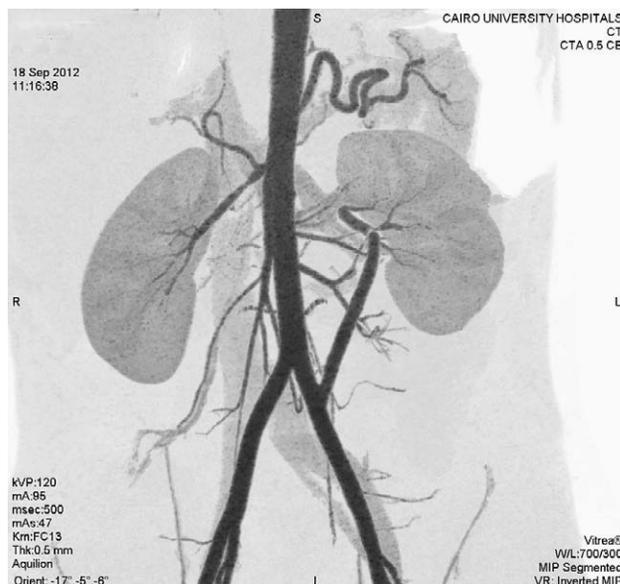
Fourteen months follow-up computed tomography angiography showing patent angioplasty on the right side and patent bypass on the left side.
